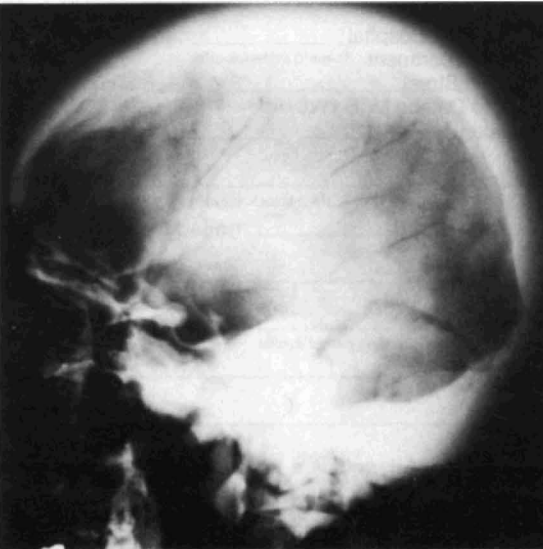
Lateral skull radiograph showing increased width and density in the calvarium, most conspicuous in the occipital region.
